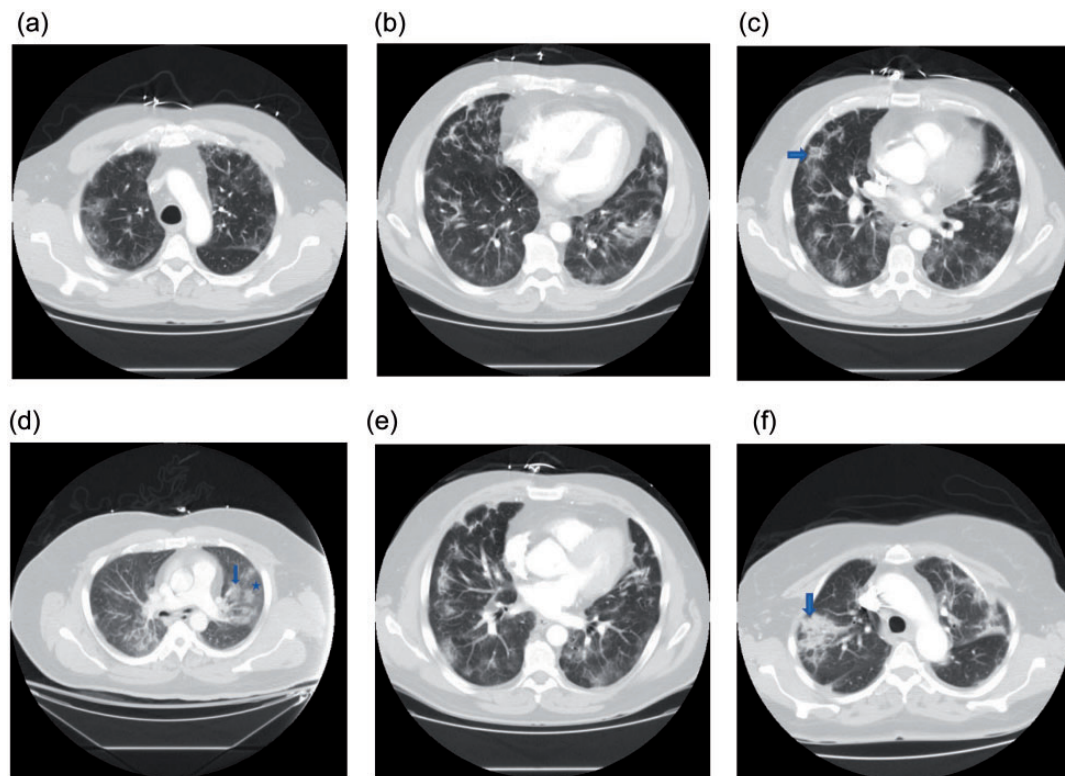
Chest CT images from COVID-19 patients at the University of Oklahoma Health Sciences Center, demonstrating the progression of the disease: (a) GGOs, (b) linear opacities, (c) reverse halo sign (blue arrow), (d) consolidation (blue arrow) in setting of GGOs (blue star), (e) crazy-paving pattern (GGOs with interstitial changes), and (f) consolidation (blue arrow).
